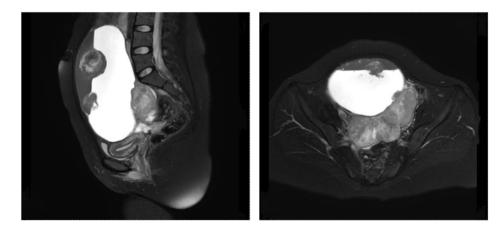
Magnetic resonance imaging (MRI) of Patient 1 reveals a large ovarian mass measuring approximately 13.0×13.8×21.1 cm, with imaging characteristics consistent with malignant transformation of a mature cystic teratoma
